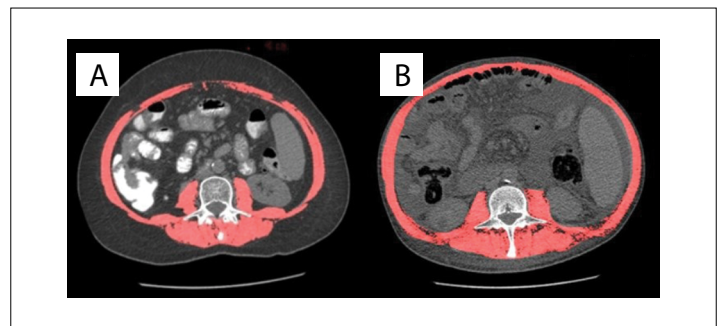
Cross-sectional area of third lumbar vertebra (L3) on abdominal computed tomography in a patient with sarcopenia ($32.17 \text{ cm}^2/\text{m}^2$) (A) and a patient without sarcopenia ($52.3 \text{ cm}^2/\text{m}^2$) (B).
